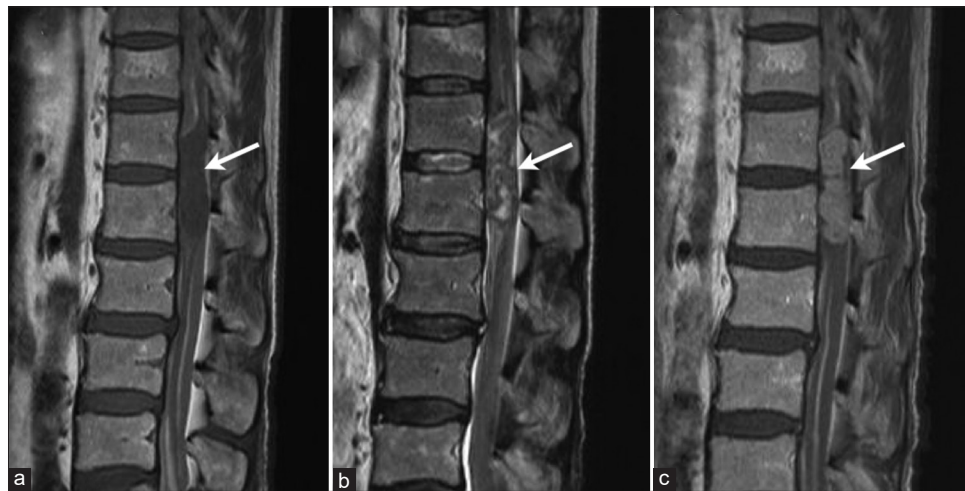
Sagittal images of T2- (a), T1- (b), and Gd-enhanced T1-weighted MRI (c). The tumor mass with iso-intensity on T1-weighted image and mixed intensity on T2-weighted image was located at the T12-L1 level and occupied the spinal canal (arrows).
